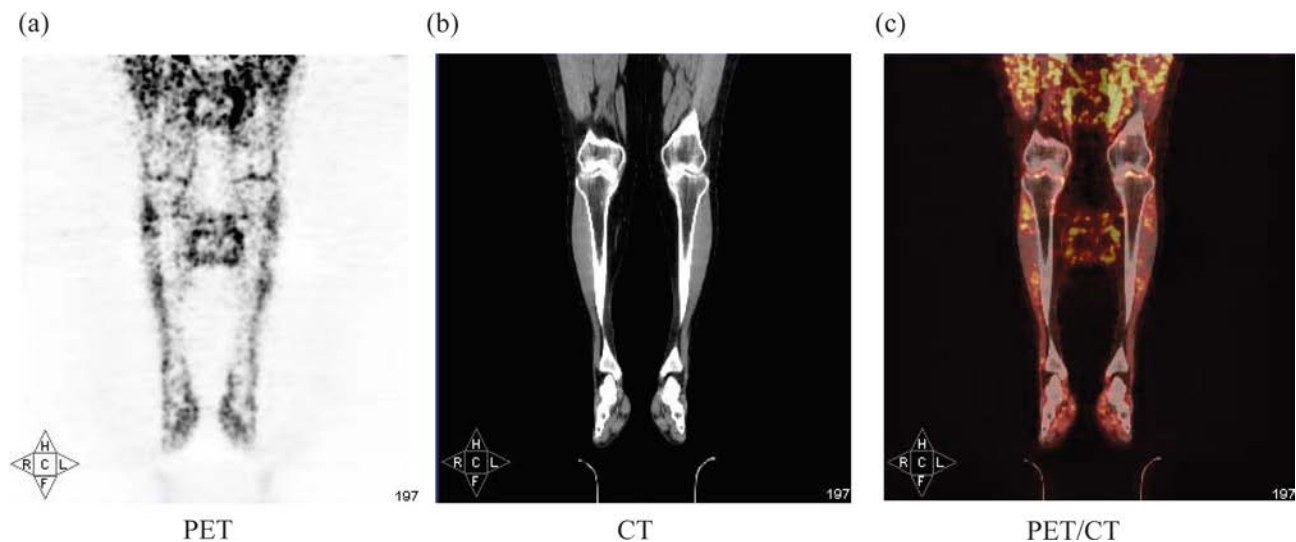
Reconstructed PET (a), CT (b) and fused PET/CT (c) images demonstrating incidental local activity misplacement in a split protocol study.
